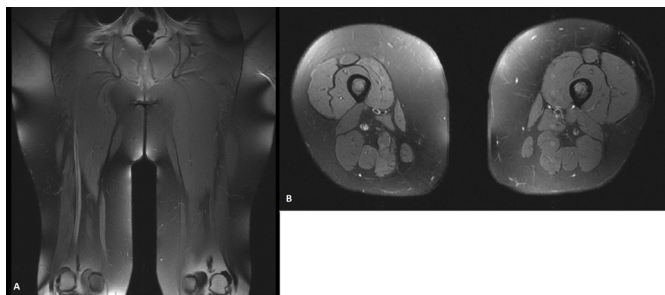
(A) Coronal and (B) axial T2-weighted MRI of the lower limbs showing hypertrophy and increased signal intensity in the right sciatic nerve throughout the thigh.
